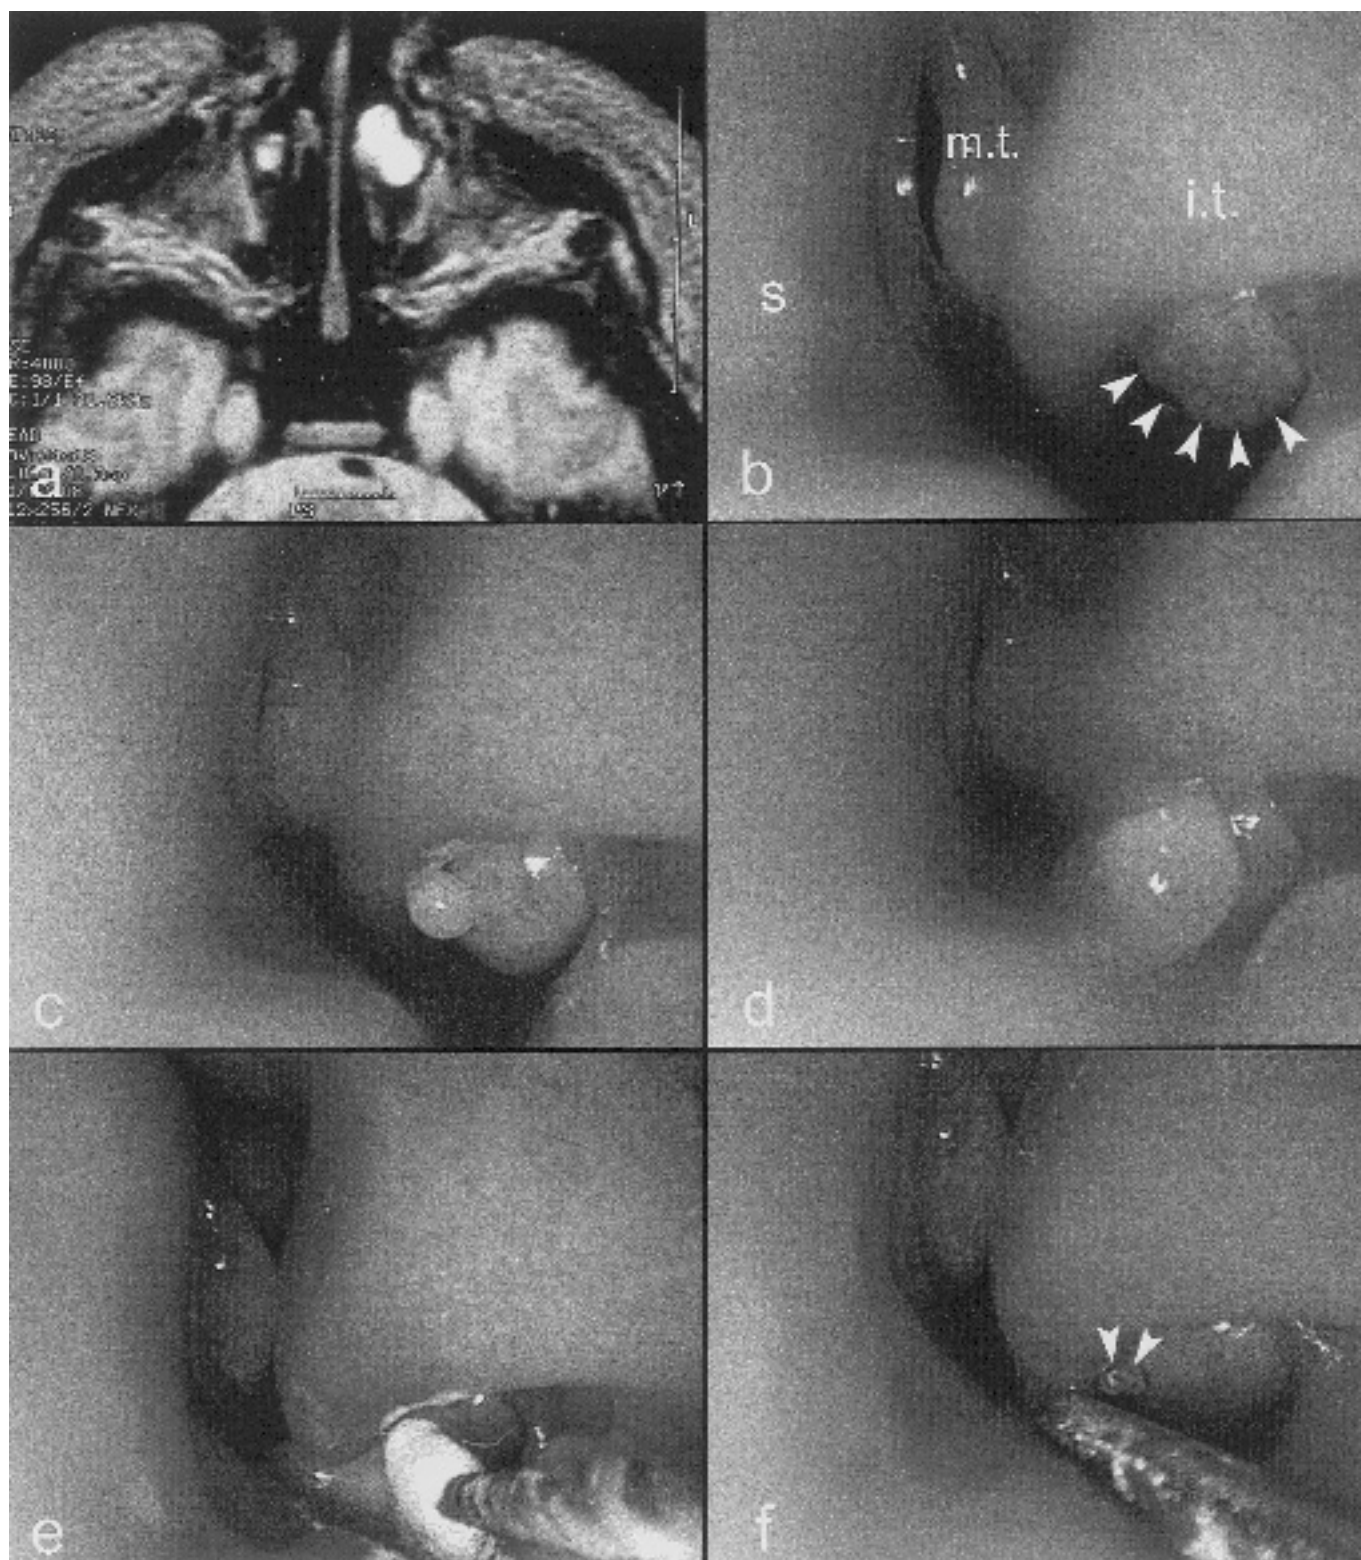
a) axial MRI (T2-weighted) of a bilateral dacryocystocele with intranasal extension with more significant finding on the left side. b) endonasal tumor in the region of the left nasal meatus (arrows). c,d) whitish concentrated secretion from the lacrimal duct after rinsing the lacrimal duct with normal saline. e) smear probe for bacteriologic diagnosis. f) aspiration of secretion and description of the opening of the lacrimal duct in the region of the lower nasal meatus after rinsing (arrows). s=nasal septum, m.t.=middle turbinate, i.t.=inferior turbinate.
